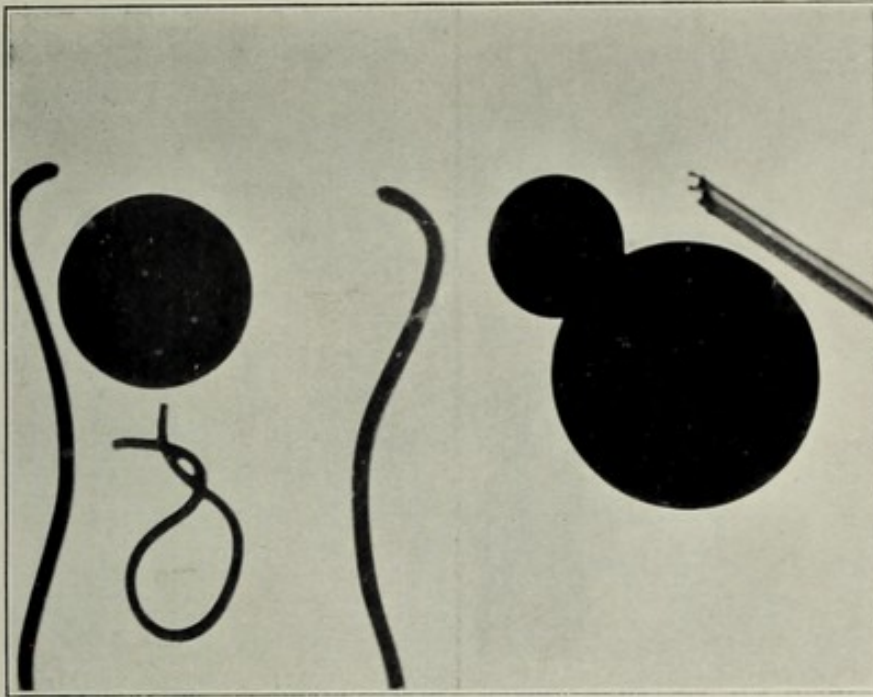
Radiographic ambiguity.*
